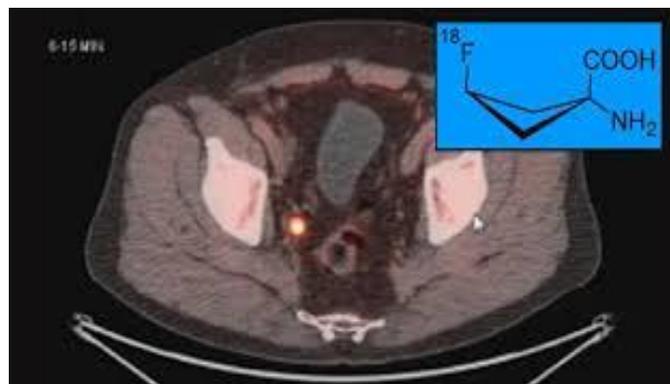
Axumin imaging via CT scan, showing areas of cancer in red. Blue inset is the FACBC-fluciclovine compound structure.
